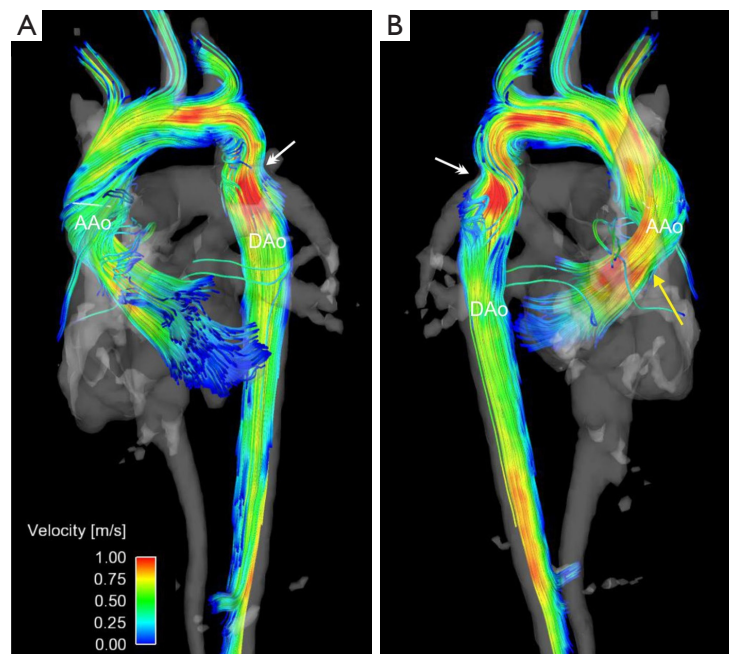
4D flow MRI in a 3.5-year-old pediatric patient with BAV and aortic coarctation at the distal arch/proximal descending aorta junction. Systolic blood flow was visualized by 3D streamlines in anterior (A) and posterior (B) views demonstrating a high velocity flow jet in the ascending aorta and exaggerated right handed helical flow (yellow arrow). Note the significant flow derangement at the site of the coarctation with high velocity flow jets and throughout the region as well as non-laminar flow features both proximal and distal to coarctation (white double arrow). Using retrospective 4D flow MRI quantification, peak flow velocity in the mid-ascending aorta was found to be 1.16 m/s, while the post-coarctation peak velocity was measured at 1.34 m/s. BAV, bicuspid aortic valve; MRI, magnetic resonance imaging.
